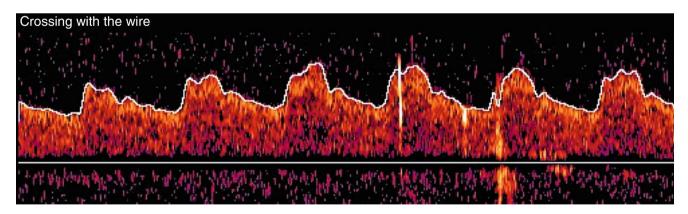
This shows small subtle microembolic signals (*MESs*) coincident with advancing the wire through the lesion. These MESs are shown as bright signals, the most prominent seen in the fourth complete Doppler pulse sequence
